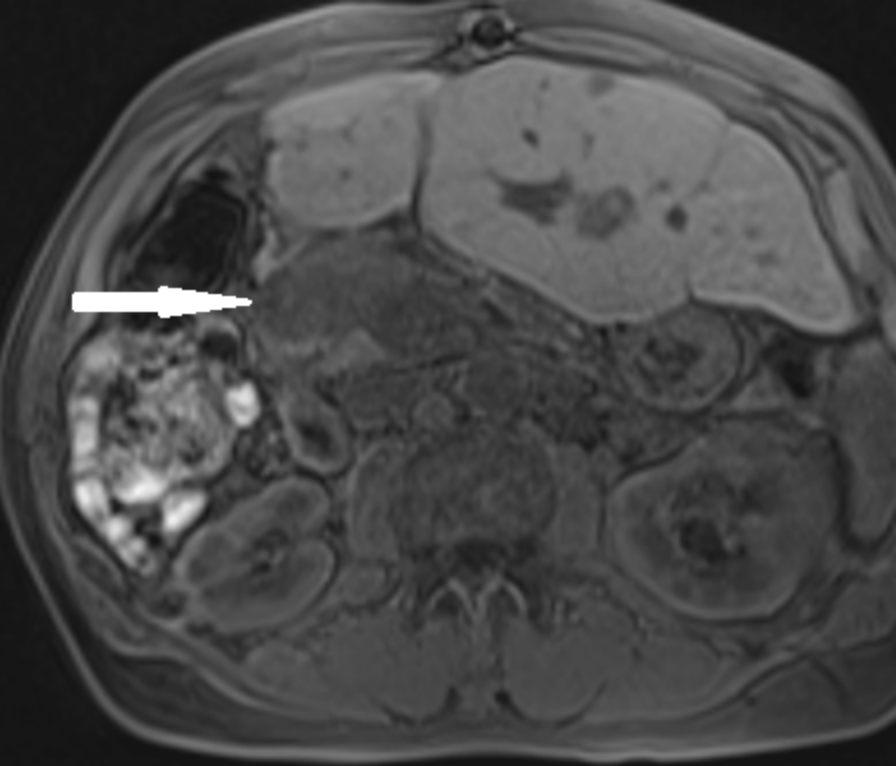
Magnetic resonance imaging (MRI) examination in an 86-year-old man with acinar cell carcinoma (ACC) of the pancreatic head. A, Fat-saturated T1-weighted MR image of the abdomen in the transverse plane shows large tumor (arrow) of the pancreatic head that is hypointense relative to the pancreatic parenchyma. B, Fat-saturated T1-weighted MR image of the abdomen in the transverse plane at a upper level than in A reveals that the pancreas shows normal appearance with no dilatation of the Wirsung duct. C, T2-weighted MR image in the transverse plane shows that the tumor (arrow) is isointense relative to the pancreatic parenchyma. D, T1-weighted MR image of the abdomen in the transverse plane obtained after intravenous administration of a gadolinium chelate during the portal venous phase shows heterogeneous and mild enhancement and complete tumor encapsulation (arrow). E, F, Diffusion-weighted MR images of the abdomen in the transverse plane obtained with b values of 50 s/mm² (E), and 1000 s/mm² (F) show hyperintense tumor (arrows) indicating restricted diffusion. The tumor has an apparent diffusion coefficient of 0.834×10^{-3} mm²/s. G, T1-weighted MR image of the abdomen in the transverse plane obtained after intravenous administration of a gadolinium chelate shows duodenal involvement (arrow) by tumor. H, Photograph shows gross appearance of ACC after surgical resection. Arrow indicates tumor capsule. Arrowhead shows duodenal involvement.
